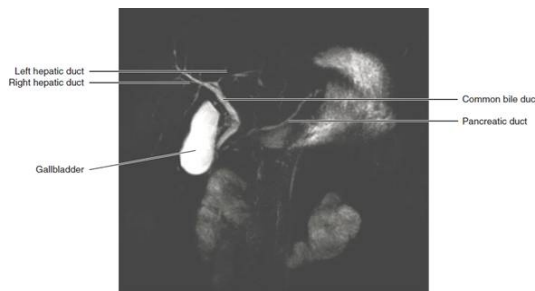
Normal MRCP. Highly T2-weighted MR sequence which shows fluid within the pancreaticobiliary system.
